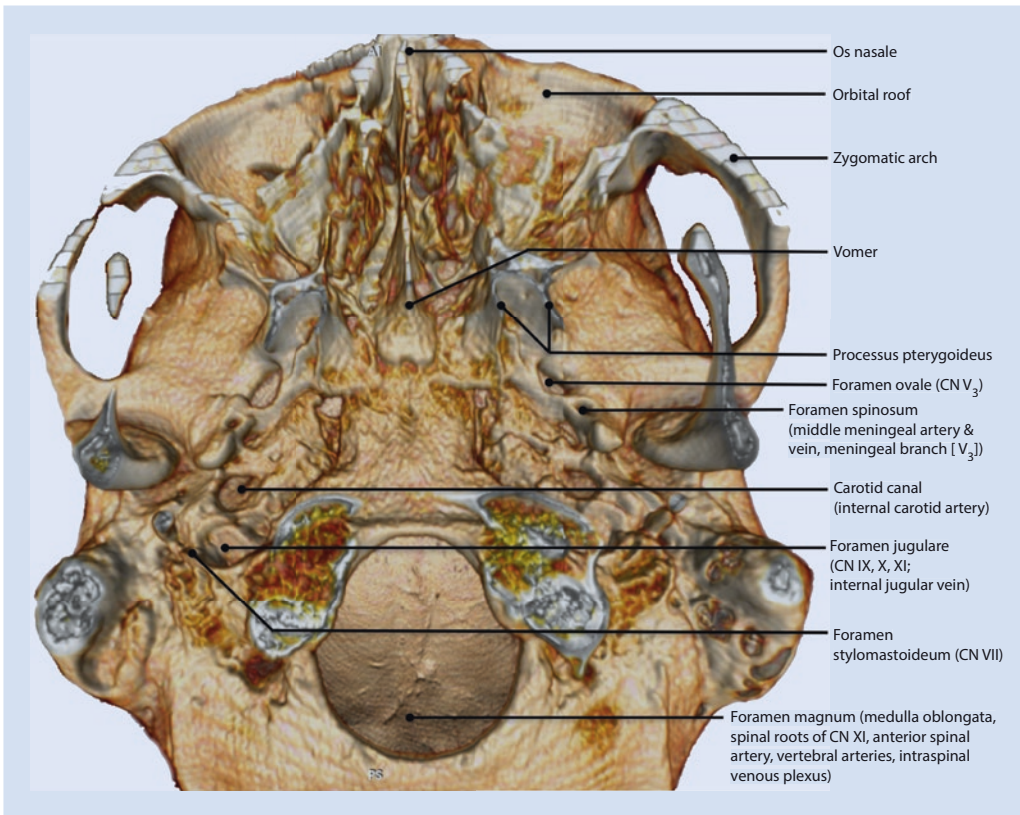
Inferior view of the osseous skull base with anatomical landmarks and the most important openings for the passage of neurovascular structures (3D reconstruction of a skull base CT scan)
